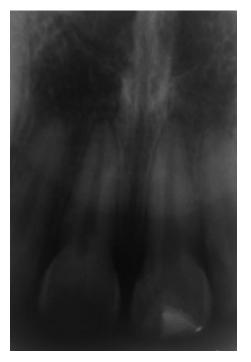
Radiographic image 1 year after reattachment.
